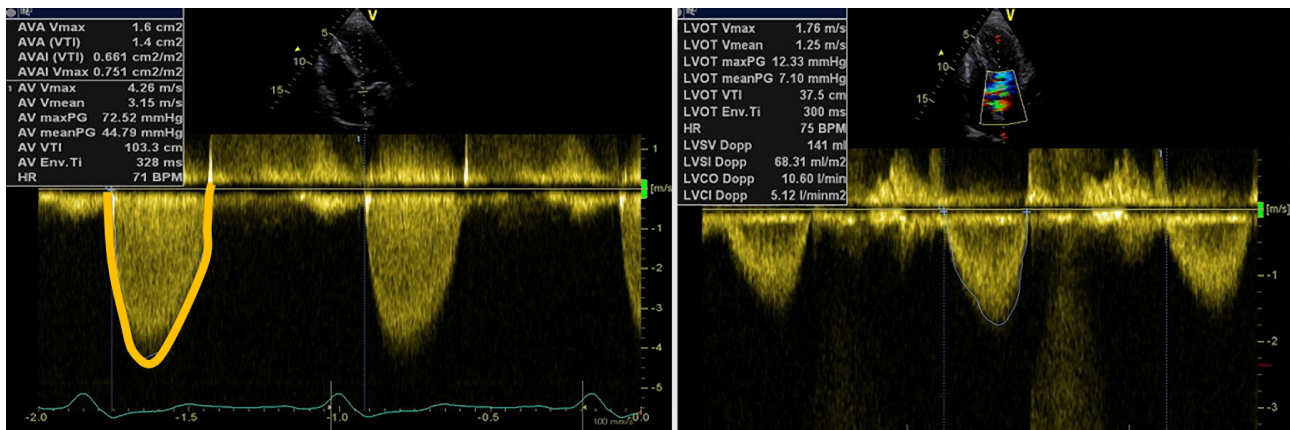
Echocardiography – continuous and pulse wave Doppler tracings of the aortic valve interrogation. Aortic valve area (AVA) calculation by continuity equation considering the following parameters – LVOT diameter (20 mm), LVOT VTI (37.5 cm) and Ao VTI (103.3 cm). The indexed AVA value is significant for severe aortic valve stenosis. AoVTI - Aortic velocity time integral; LVOT VTI - Left ventricular outflow tract velocity time integral.
